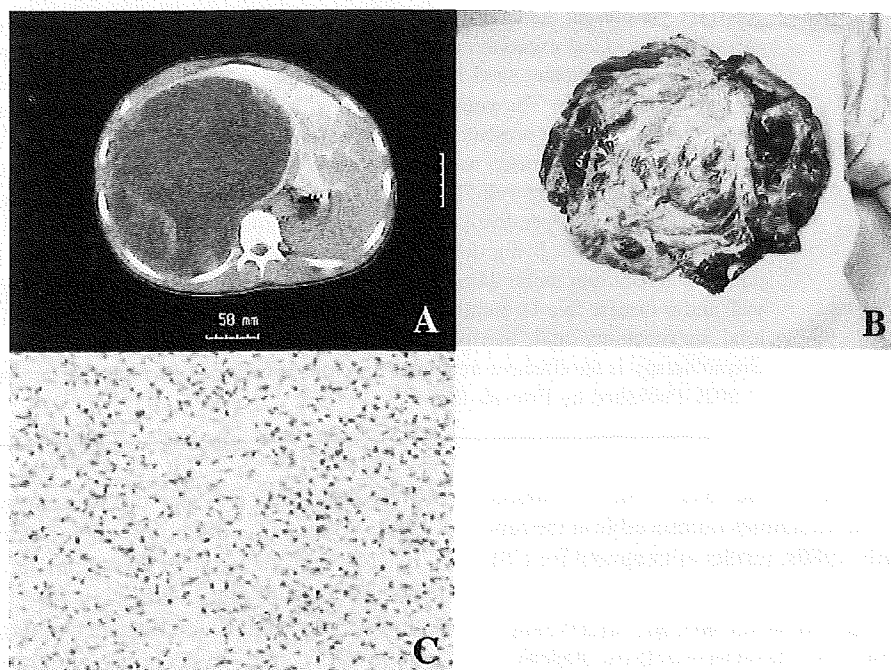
A, Enhanced abdominal CT scan shows a large low attenuated mass in the right lobe of the liver. B, The tumor was composed of friable necrotic tissue, gelatinous material, and pseudocapsule. C, Diffuse proliferation with immature spindle cells.
